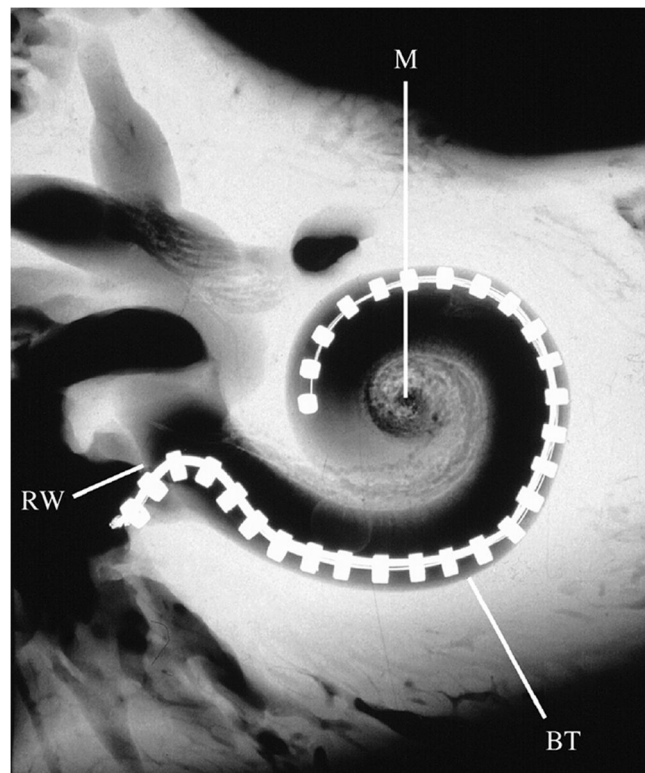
X-ray image of a cochlear implant in a human cochlea. This implant includes 29 stimulating electrodes. M, modiolus; RW, round window or entry point to the basal turn of the cochlea; BT, basal turn of the cochlea.
